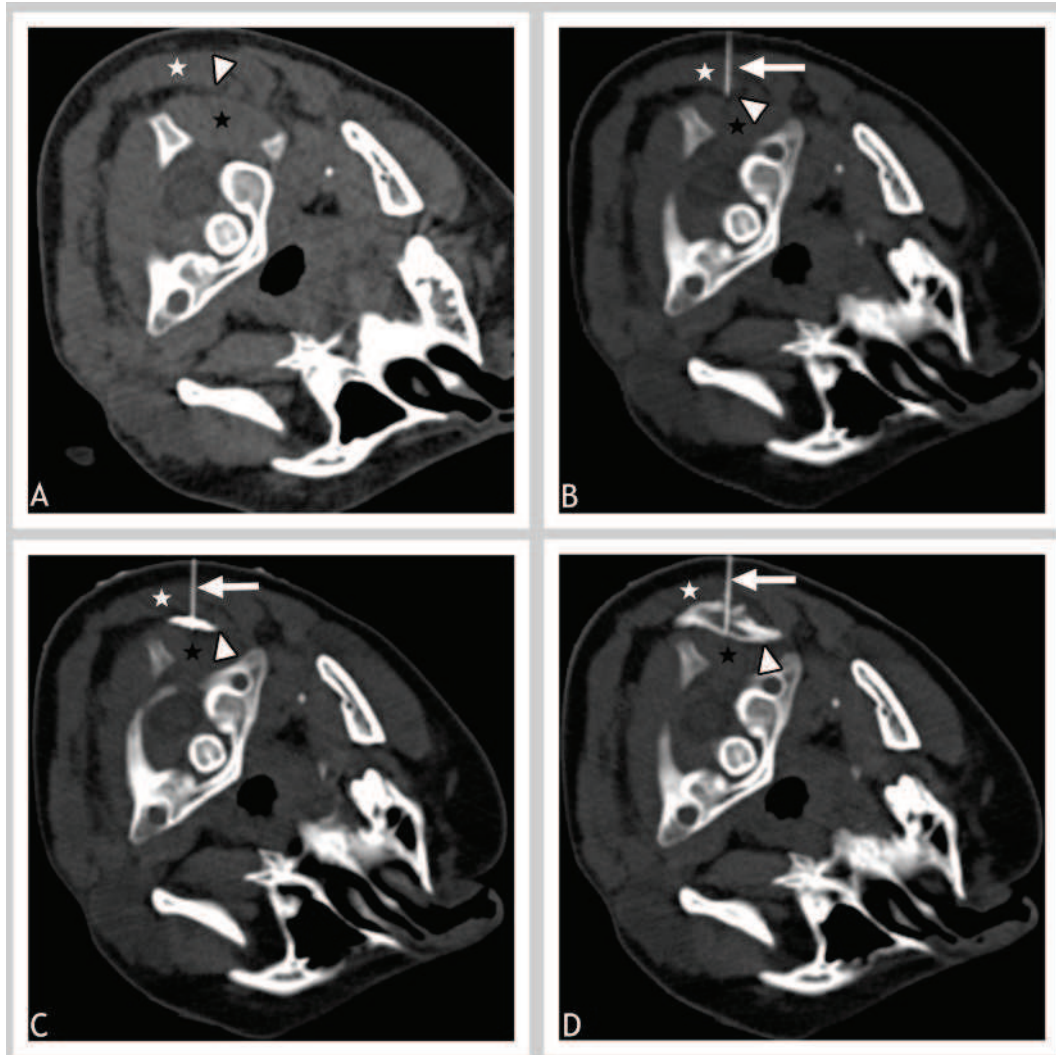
Planning non enhanced CT showing the target of infiltration: fatty space (white arrow head) between inferior oblique (Black Star) and semispinalis (white star) muscles.
